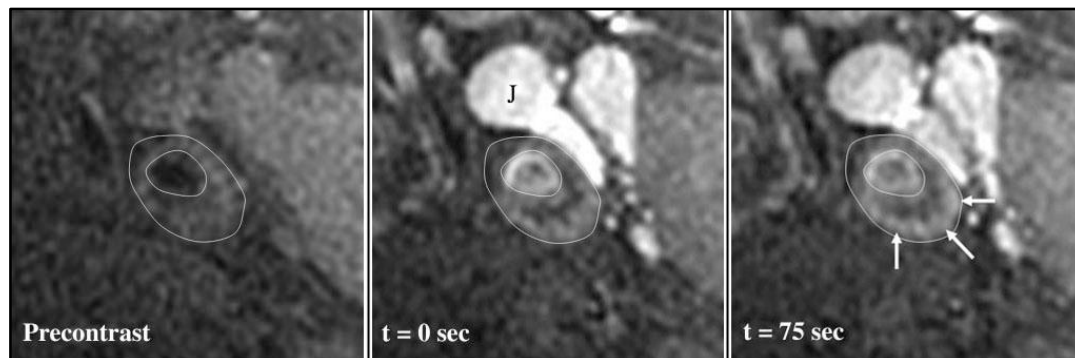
MRI investigation of carotid atherosclerotic plaque using gadolinium-based contrast agent; Precontrast image (left), contrast enhanced at bolus arrival (middle) and 75 sec later (right) (adapted by Kerwin *et al*, 2006)
